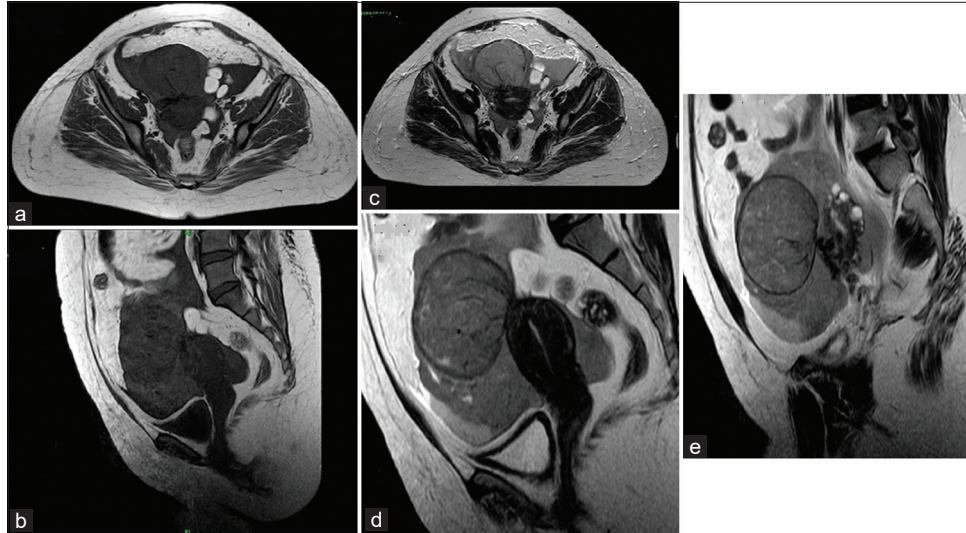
Magnetic resonance imaging (MRI) (a) axial and (b) sagittal section at the level of pelvis shows well-defined pedunculated subserosal T1 iso-hypo intense mass lesion noted, arising from the anterior aspect of uterine fundus. MRI (c) axial and (d) sagittal section at the level of pelvis shows well-defined pedunculated sub-serosal T2 hyperintense mass lesion noted, arising from the anterior aspect of uterine fundus measuring. MRI T2 (e) sagittal section shows well-defined pedunculated sub-serosal fibroid with prominent intralesional flow voids-suggestive of feeding vessels.
